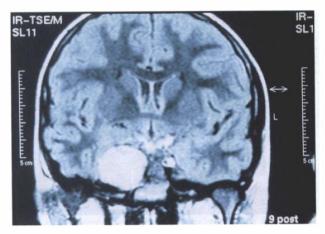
Coronal T2-weighted MRI scan showing the 5 cm trigeminal schwannoma.
